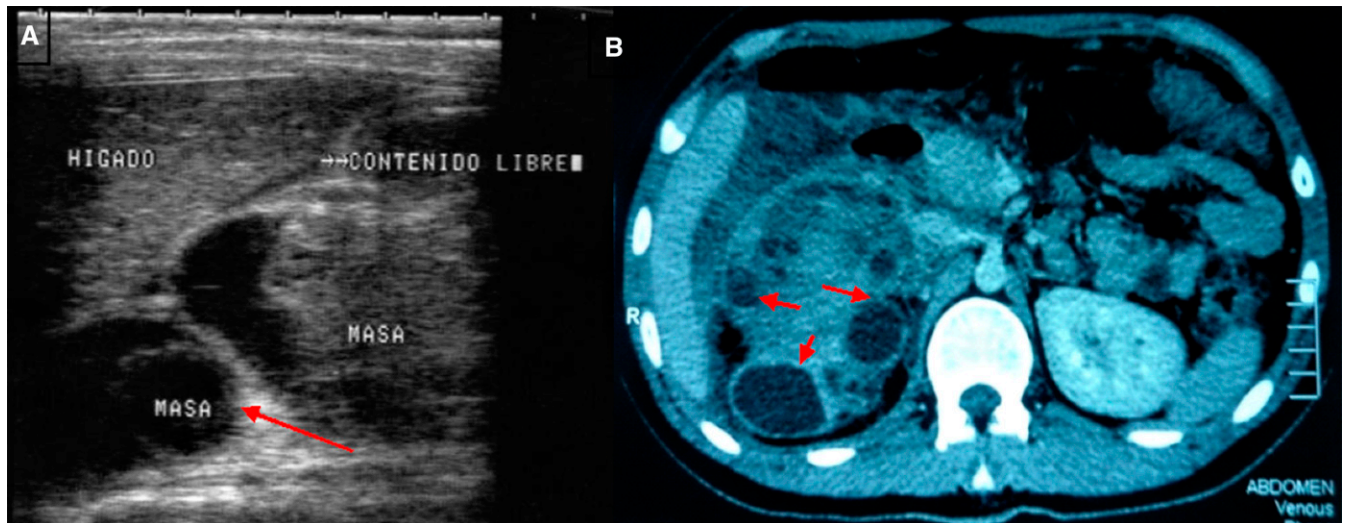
Diagnostic aid images (A) ultrasonography and (B) computerized axial tomography. (A) Echogenic image of irregular borders in the right renal sinus, fluid in the peritoneal cavity, and loss of corticomedullary differentiation. (B) Contrast tomography showing several liquid-density images in the right renal parenchyma separated by higher density septa, with loss of morphology of the right kidney and renal pelvis without contrast enhancement. This figure appears in color at www.ajtmh.org.
